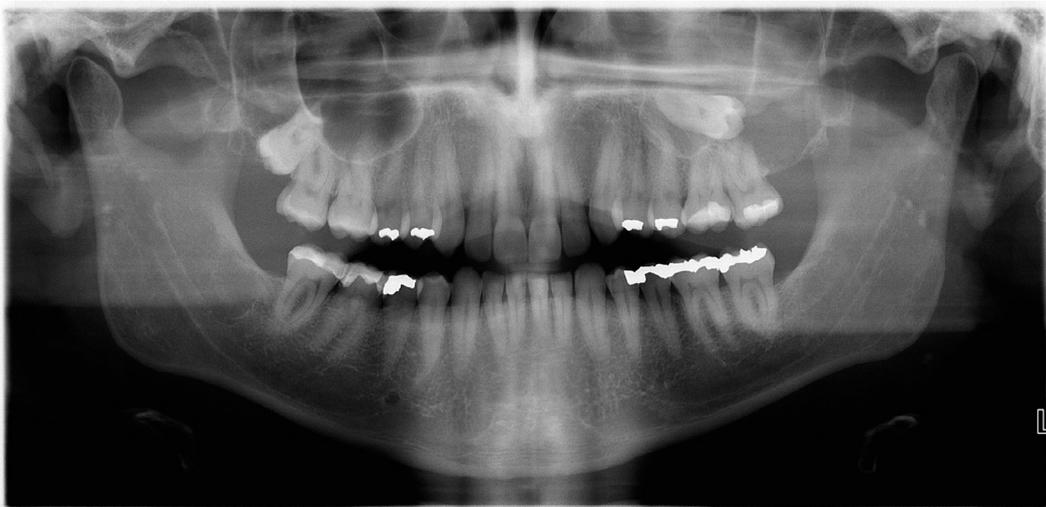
Preoperative panoramic dental X-ray showing the ectopic position of the upper left third molar. A widespread opacity is visible in the left maxillary sinus.
